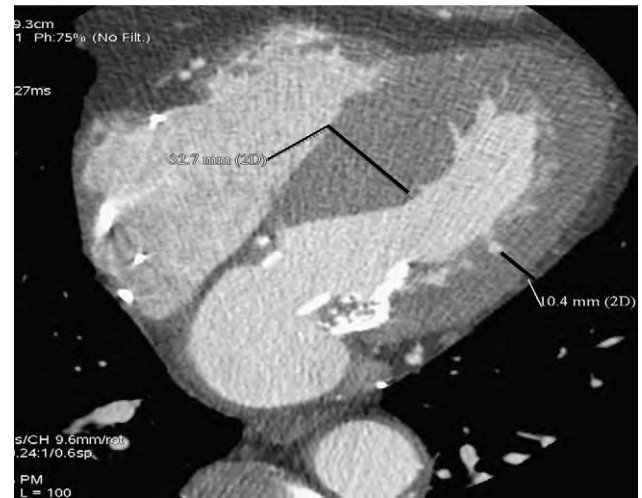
High contrast resolution on gated cardiac CT allows clear delineation of the myocardium, with sharp separation of contrast (white) and the myocardium (gray) and therefore can provide detailed characterization of the HCM phenotype. This patient with asymmetric septal hypertrophy had undergone pacemaker implantation, so CMR imaging was not possible. The lines and measurements refer to septal wall and lateral wall thickness.
